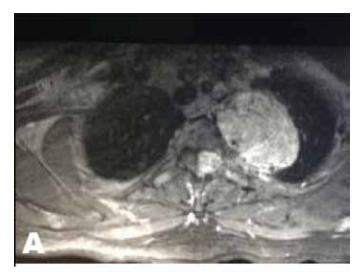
Thoracic spine magnetic resonance imaging scan showing a large dumbbell shaped tumor extending through the left T2-T3 neuroforamina with cord compression (A) Axial view, (B) Sagittal view.
